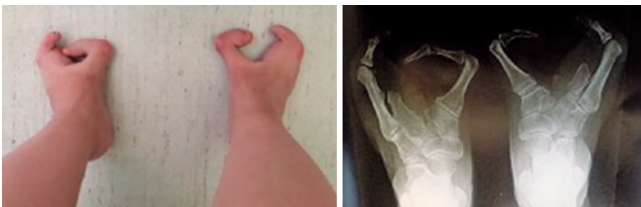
Photo and AP X-ray of the patient's feet.
